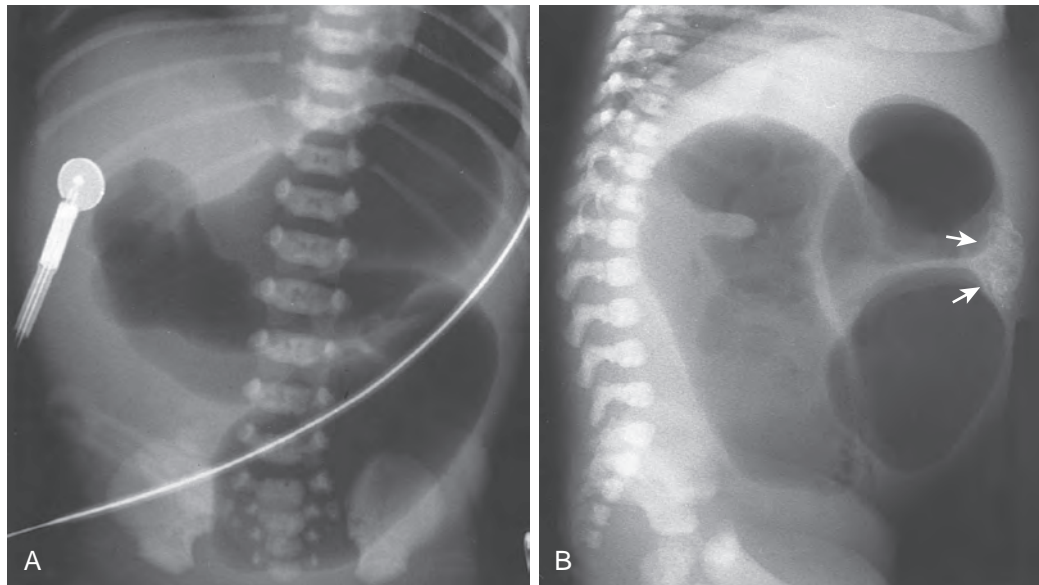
High obstruction. Anteroposterior (A) and lateral (B) abdomen radiographs in a child with jejunal atresia show several markedly distended bowel loops that fill the abdomen. The calcification along the anterior abdominal wall (arrows) indicates prior bowel perforation and meconium peritonitis.
